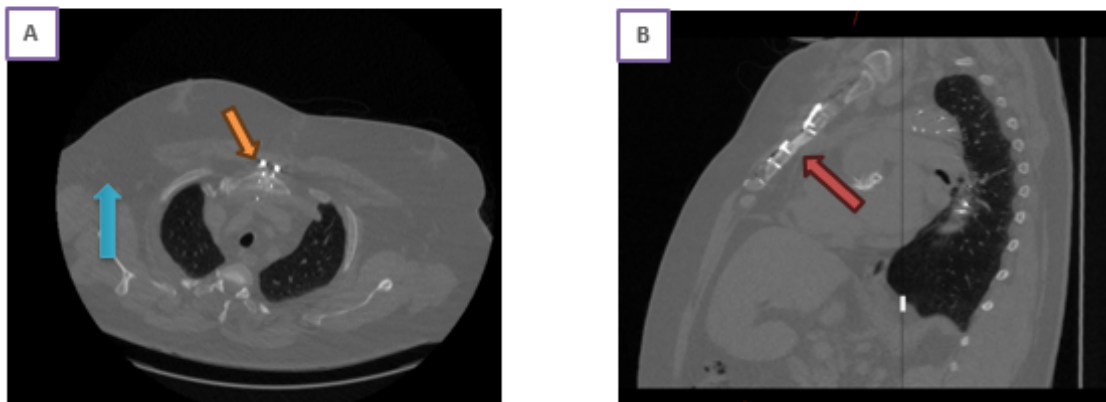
Post-operative follow-up CT scan 4 months post-procedure. A: Showing the sternal plate and screws in a stable position sternum (orange arrow) and chest wall soft tissue thickness showing the extent of obesity (blue arrow). B: Shows the appropriately sized and positioning of sternal screws in the body of the sternum (red arrow).
